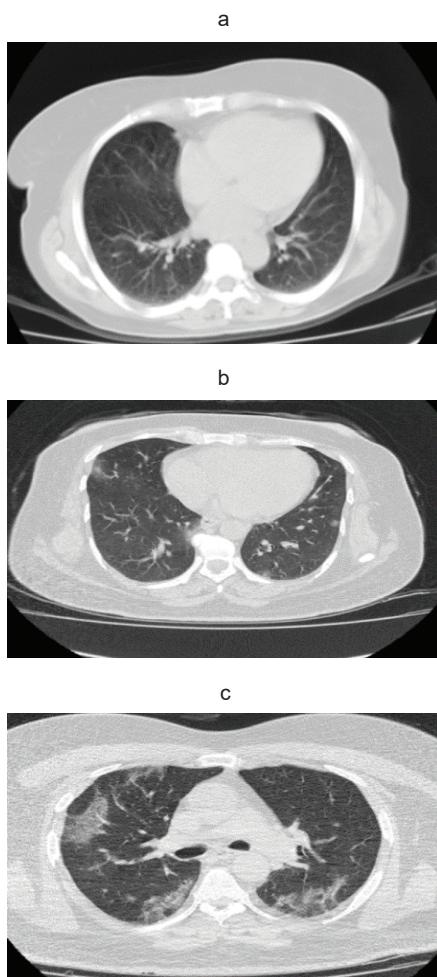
High Resolution Computed tomography (HRCT) images of (a) normal and COVID-19 infected data (b) mild cases and (c) severe cases
